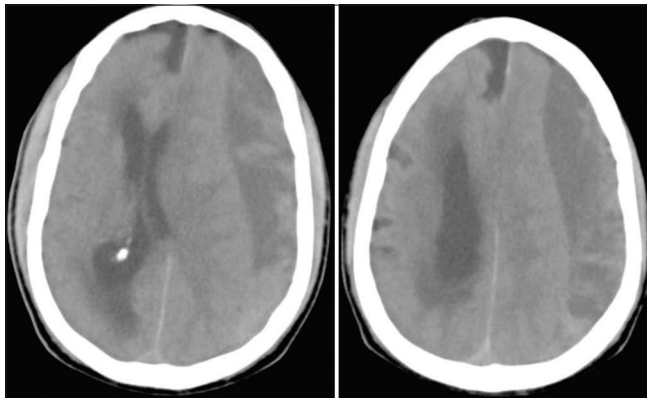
Preoperative cranial CT scan images of the third patient showing left hemispherical chronic subdural hematoma with partial effacement of the left lateral ventricle and midline shift to the right.
